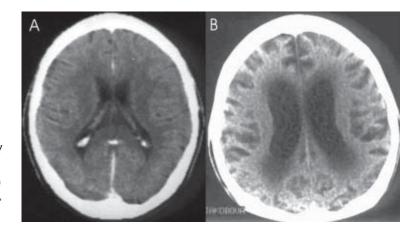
Computed tomography scans showing mild brain atrophy without any visible pathologic changes of the brain tissue, with marked progression (A) and marked brain atrophy in the final stage of the disease course (B).
